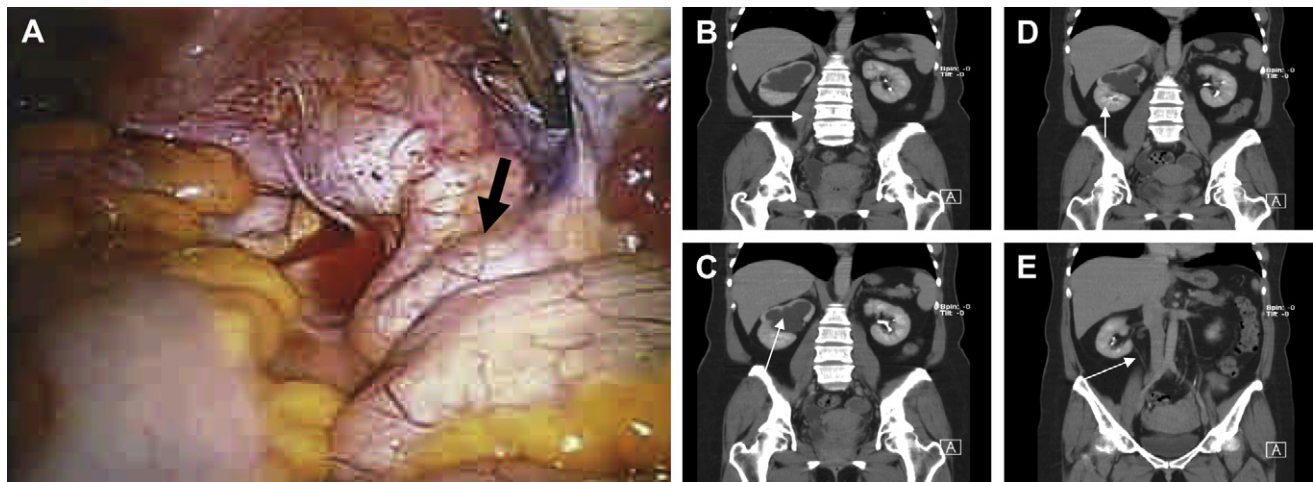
(A) Laparoscopic findings of megaureter. Arrow: ureter. (B–D) Computed tomography scan findings. Arrows in (B) indicate the megaureter, in (C) the hydronephrosis, in (D) the normal kidney, and in (E) the normal ureter.
